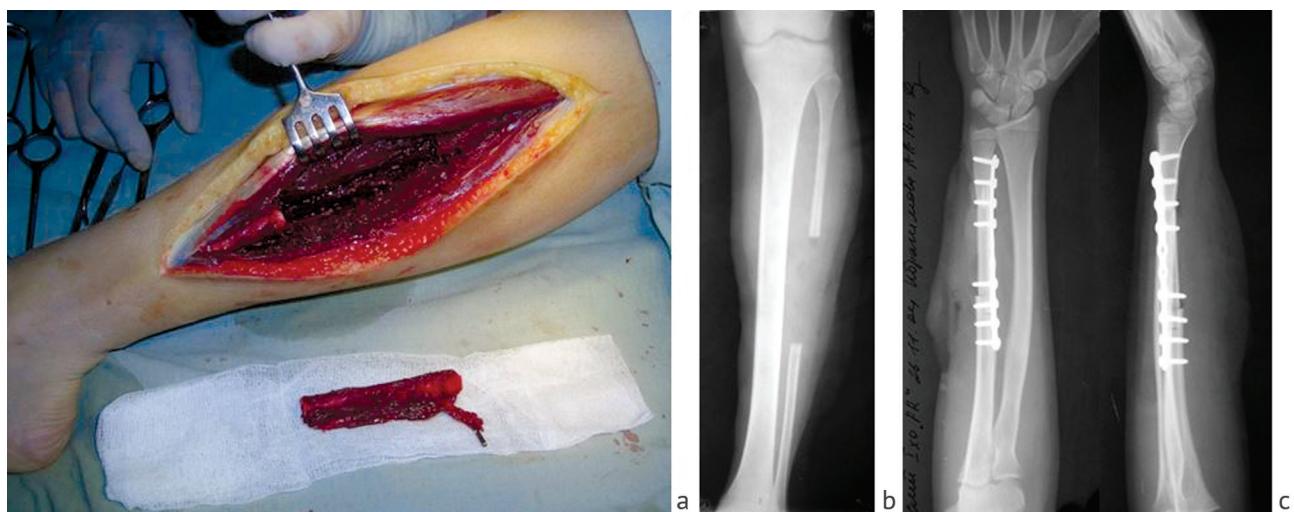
Stages of the operation: a photo of bone autograft harvesting; b intraoperative X-ray of the donor leg; c radiographs of the left forearm
